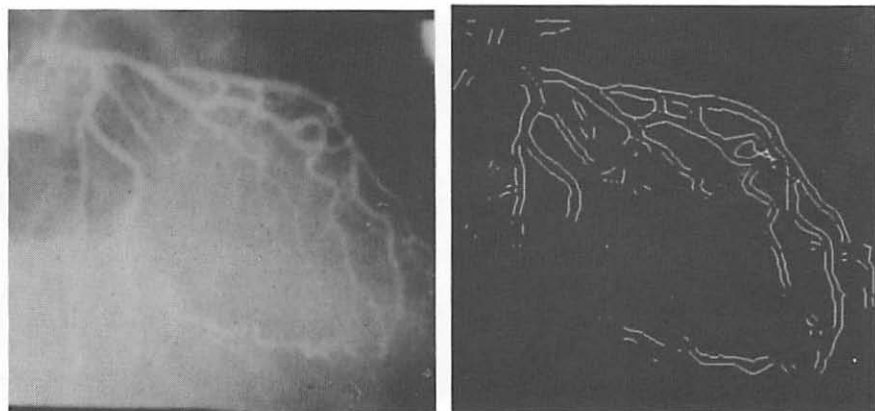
HEART: The original image is an X-ray cardiac angiogram after the injection of radio opaque dye. The identified ribbons are shown on the right.
